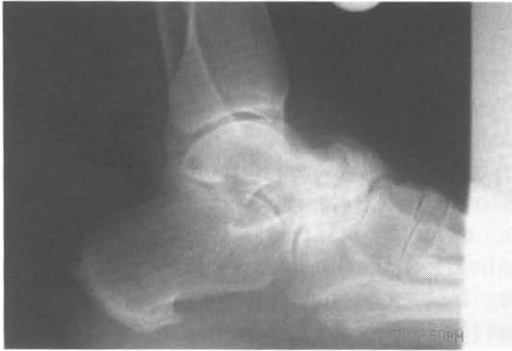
Radiograph shows talar navicular exostosis, which causes compression to the deep peroneal nerve.
